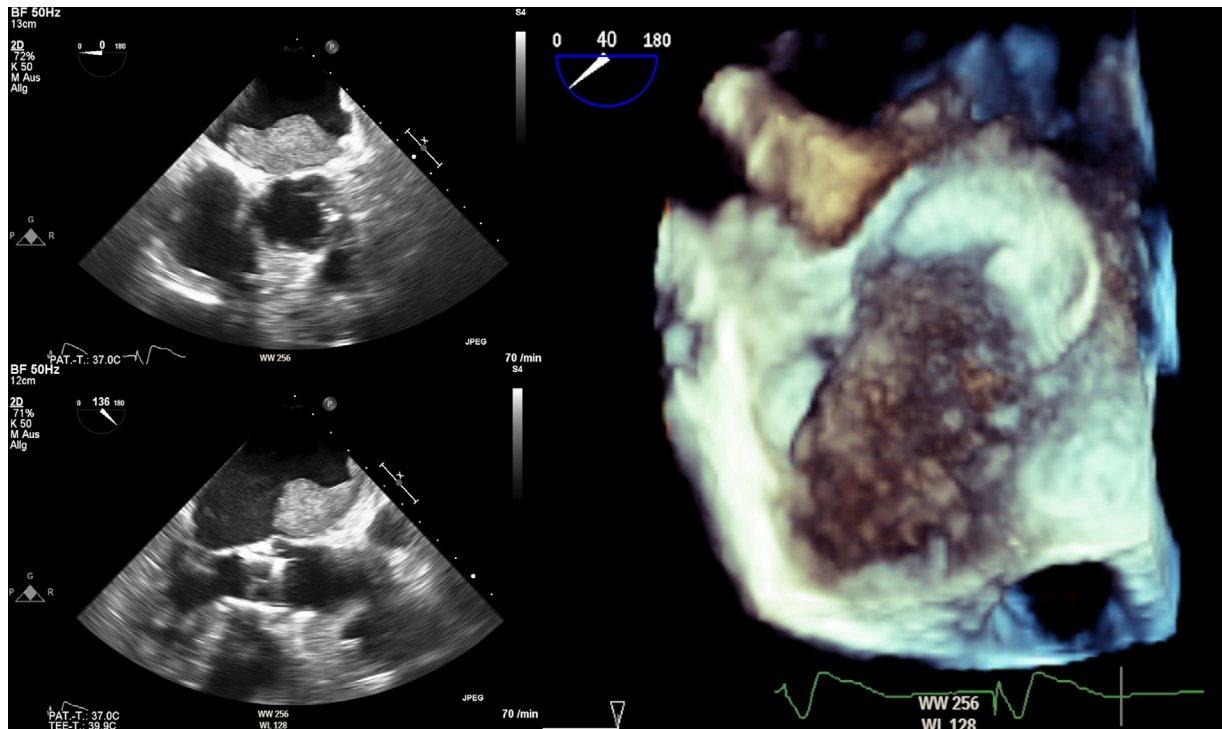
Echocardiographic images obtained in 2-dimensional and 3-dimensional transesophageal echocardiography of an 87-year-old female patient with diagnosis of a large DRT after implantation of a 20 mm Amulet Amplatzer device. DRT, device-related thrombosis.
